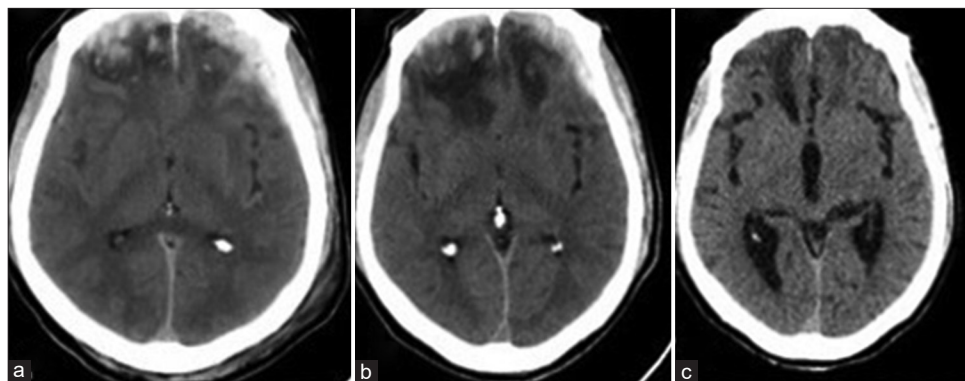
(a) Plain computed tomography (CT) brain showing small bifrontal contusions with mild focal edema. (b) CT scan performed after the onset of the headache showed an increase in perilesional edema. (c) CT scan was done 3 weeks later, showing resolution of cerebral edema.
